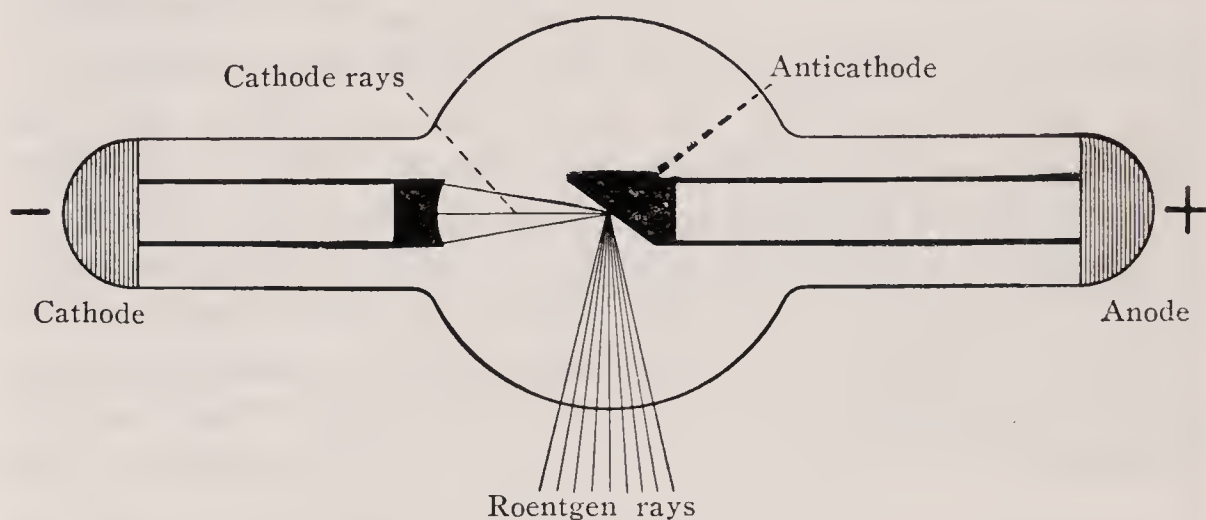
Roentgen ray tube.
